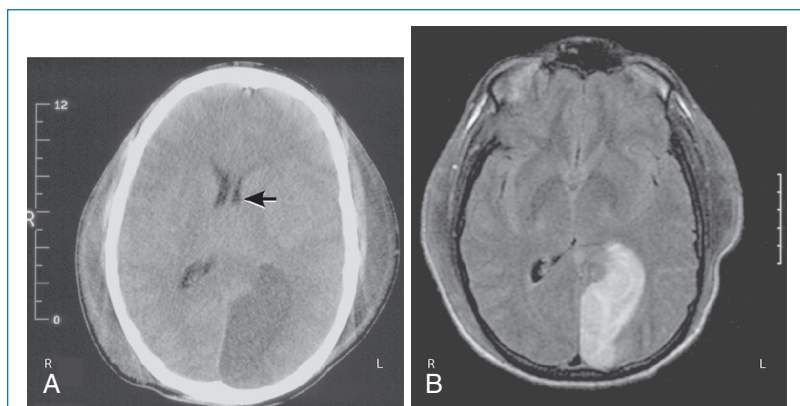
Stroke on computed tomography (CT) and magnetic resonance imaging (MRI) scans. A, The CT scan done 3 days after a stroke shows a low-density area posteriorly on the left with mass effect and clear midline shift (*arrow*). B, The MRI scan done on the same day shows the infarcted area much more clearly. (From Mettler F. *Essentials of radiology*. 2nd ed. Philadelphia: Saunders, 2004.)
